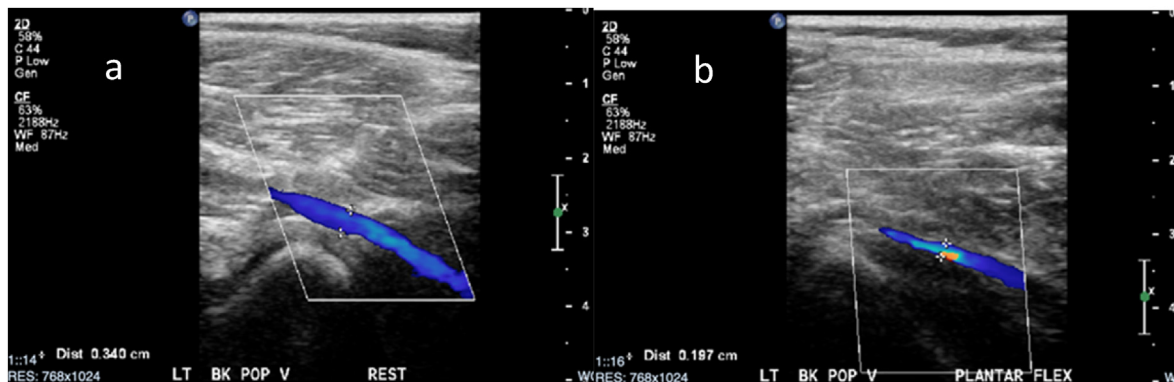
Duplex Doppler Ultrasound images of the left below-knee popliteal vein at rest (image a) and with plantarflexion (image b), demonstrating decreased venous diameter and turbulent flow with plantarflexion.
